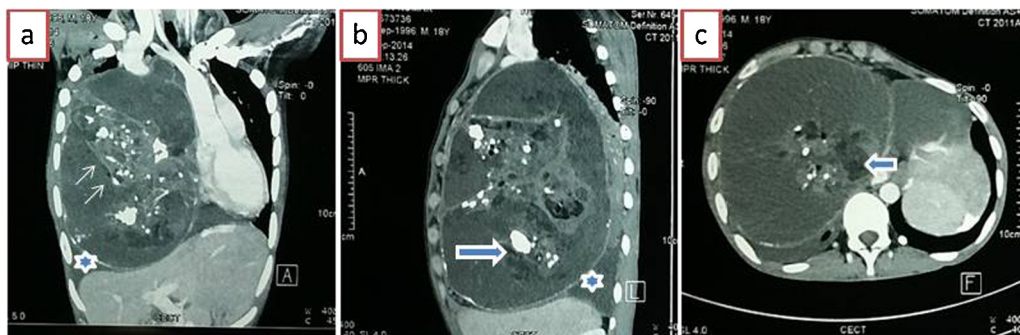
(a) Coronal, (b) lateral and (c) horizontal cut section of contrast enhanced high resolution computed tomography chest. A large heterogeneous solid cystic (black arrow) multiseptated (thin arrow head) lobulated mass lesion ($14.5 \times 10.4 \times 19.9$ cm) containing areas of soft tissues and fatty attenuation with multiple coarse calcified septal thickening (thin arrow head) is noted in right hemithorax extending from anterior mediastinum with significant contralateral mediastinal shift (a). Thin walled well-defined capsule with calcification (star) is also noted. Superior vena cava is encased in the mass but luminal patency seen. Final diagnosis anterior mediastinal mature teratoma.
